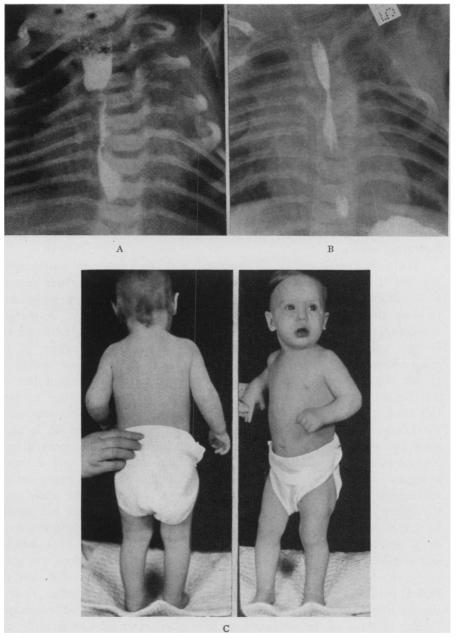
S. S., Case 19.—(A) Portable roentgenogram after ingestion of iodized oil five days after left extrapleural ligation of tracheoesophageal fistula and primary anastomosis of esophageal segments. Leakage of the anastomosis did not occur. The upper esophagus is dilated and the lumen at the site of the anastomosis is narrow. All feedings were continued by mouth. Gastrostomy and esophageal dilatation were not necessary.
